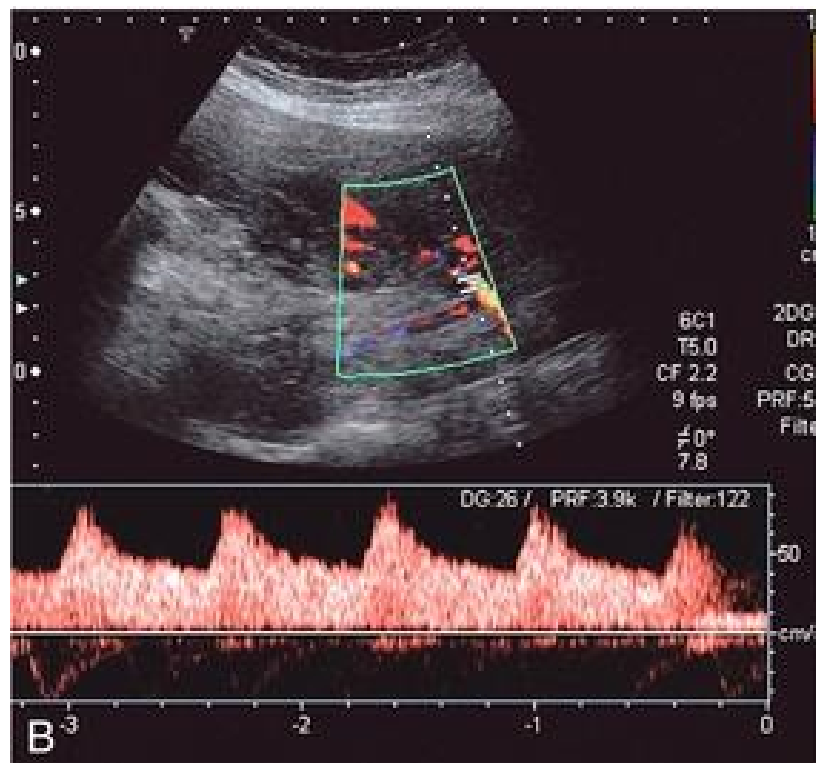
Normal uterine artery flow in the early third trimester demonstrating high diastolic flow. (Clinical Applications of Doppler Ultrasound in Obstetrics, 2015)
